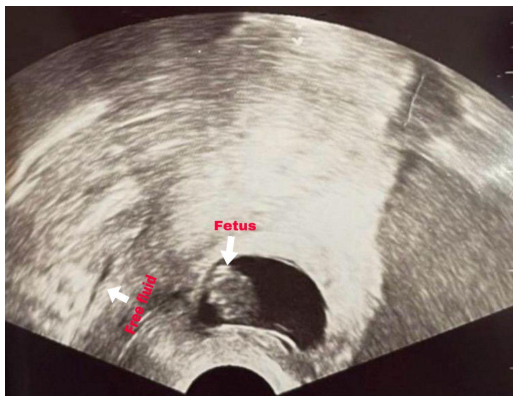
Result of transvaginal ultrasound: fetus in uterine cavity and a moderate amount of free fluid in intraperitoneal cavity
